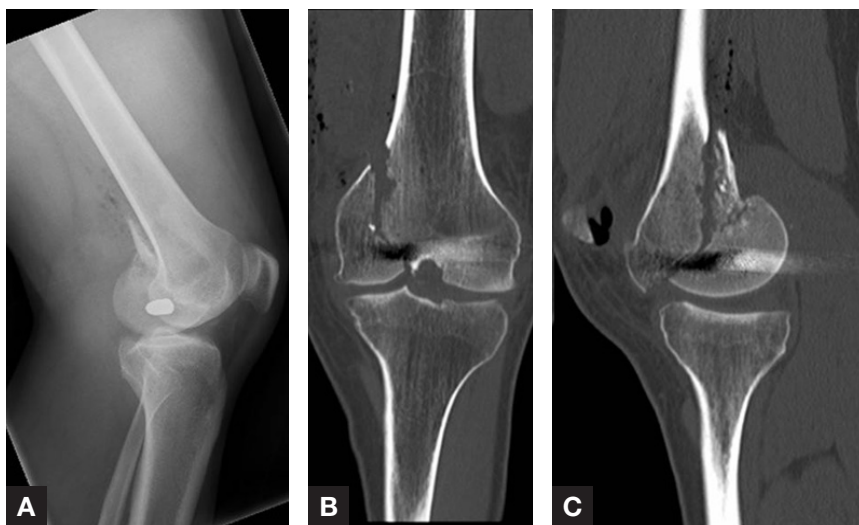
Radiographic (A) and computed tomography (B, C) evaluations of 28-year-old man with fractures of medial femoral condyle and associated comminution.
